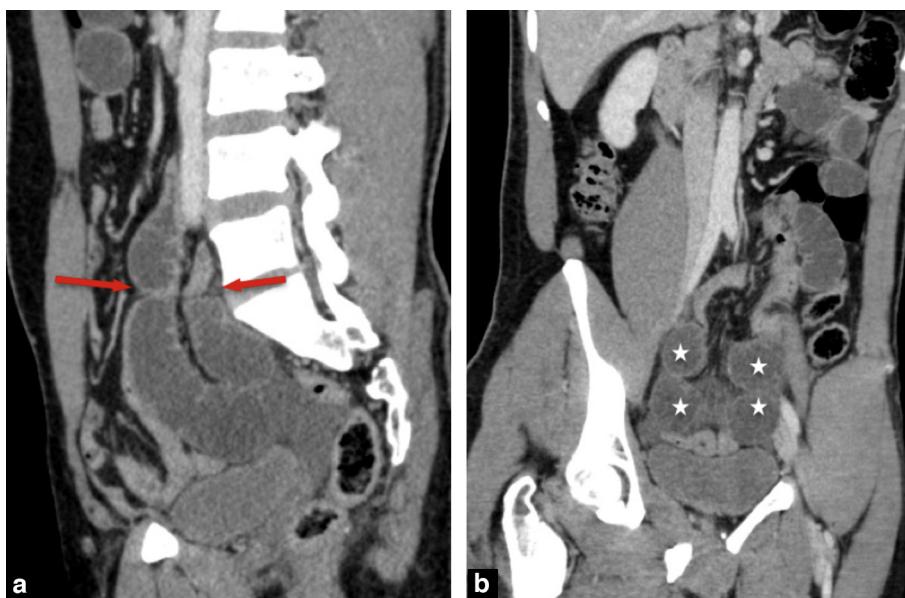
Frontal CT image of a mechanical closed loop obstruction of the small intestine. Contiguous zones of transition (right arrow) with double dilation on both sides of the place of proximal obstruction (a). Radial layout of incarcerated loops towards the place of obstruction (asterix) (b).
